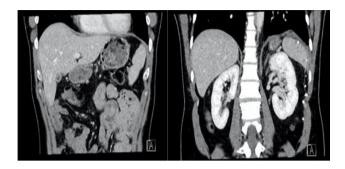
Computed tomography at 3 months follow up post repair.
